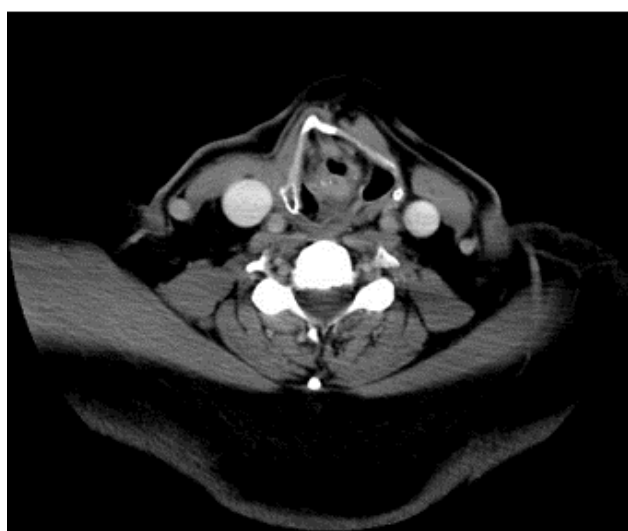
Post-treatment CT scan showing significant interval improvement.
